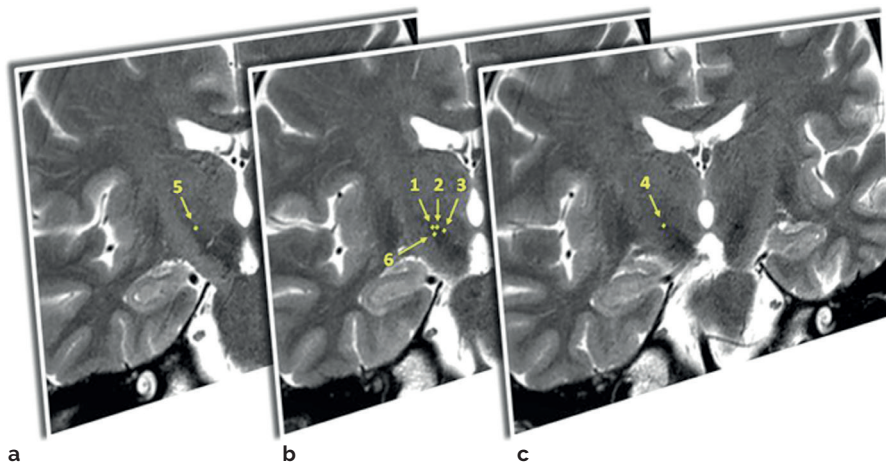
Example of three coronal 3.0 T T2-weighted MRI images, (b) the central image closest to the y-coordinate of the stereotactic target on the right side, (a) the image 2 mm more posterior and (c) 2 mm more anterior. In these images the dorsal (1 – 5) and lateral (6) border points of the right STN are identified by the neurosurgeon.
